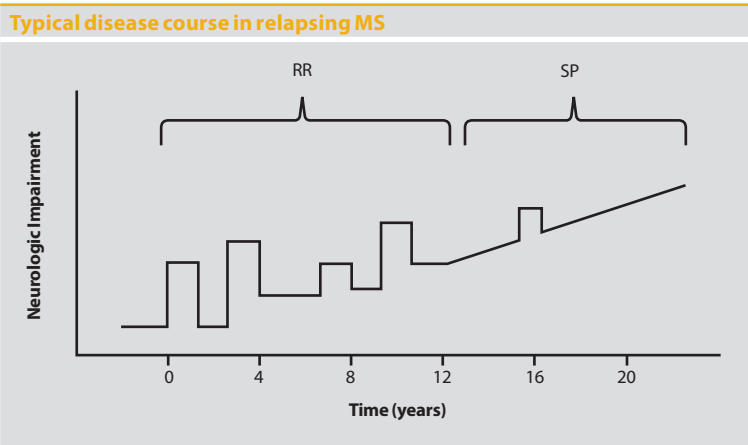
Typical disease course in relapsing MS. In 70–80% of patients, MS begins with a RR course. The initial relapse is a CIS. The diagnosis of RR MS is confirmed when a second clinical or MRI event occurs. In RR MS disability accrues from incomplete recovery from relapses. Relapses vary in neurologic manifestations, frequency, severity, and degree of recovery. Most patients with RR MS evolve into a SP course 10–15 years after onset. The transition from RR to SP MS is indistinct, with decreasing relapse frequency and onset of gradual worsening between relapses. Late in the disease, there is gradual progression without relapses. CIS, clinically isolated syndrome; RR, relapsing–remitting; SP, secondary progressive.
